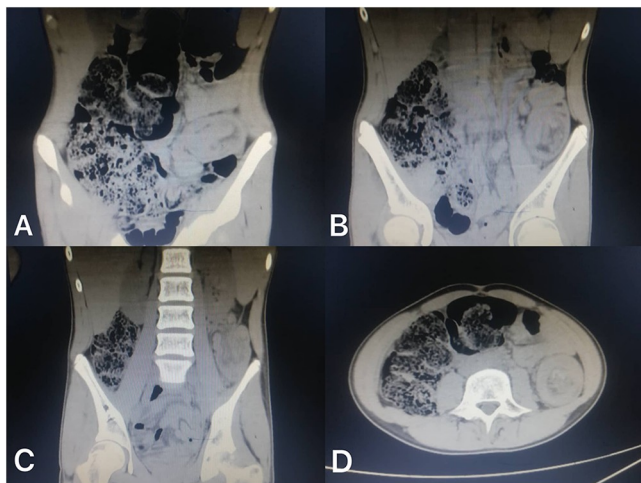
(A–D) Computed tomography scan: Performed preoperatively upon admission of the patient. (B) Showing a mass at the level of the descending colon with severe dilation that appeared on the level of the ascending and transverse colons. (C) Computed tomography scan in the longitudinal section showing the Pseudokidney sign which indicates colon intussusception as an initial diagnosis. (D) Computed tomography scan in the transverse section showing the Target sign which indicates colon intussusception as an initial diagnosis.
